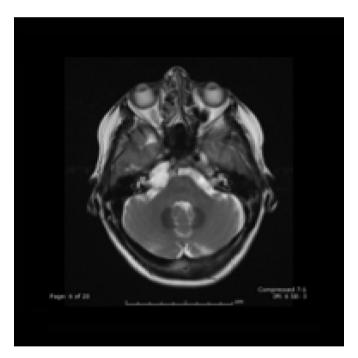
T2-weighted axial MRI of Patient 1 showing a hyperintense lesion extending from the right petrous region into the cerebellopontine angle abutting the brainstem.
